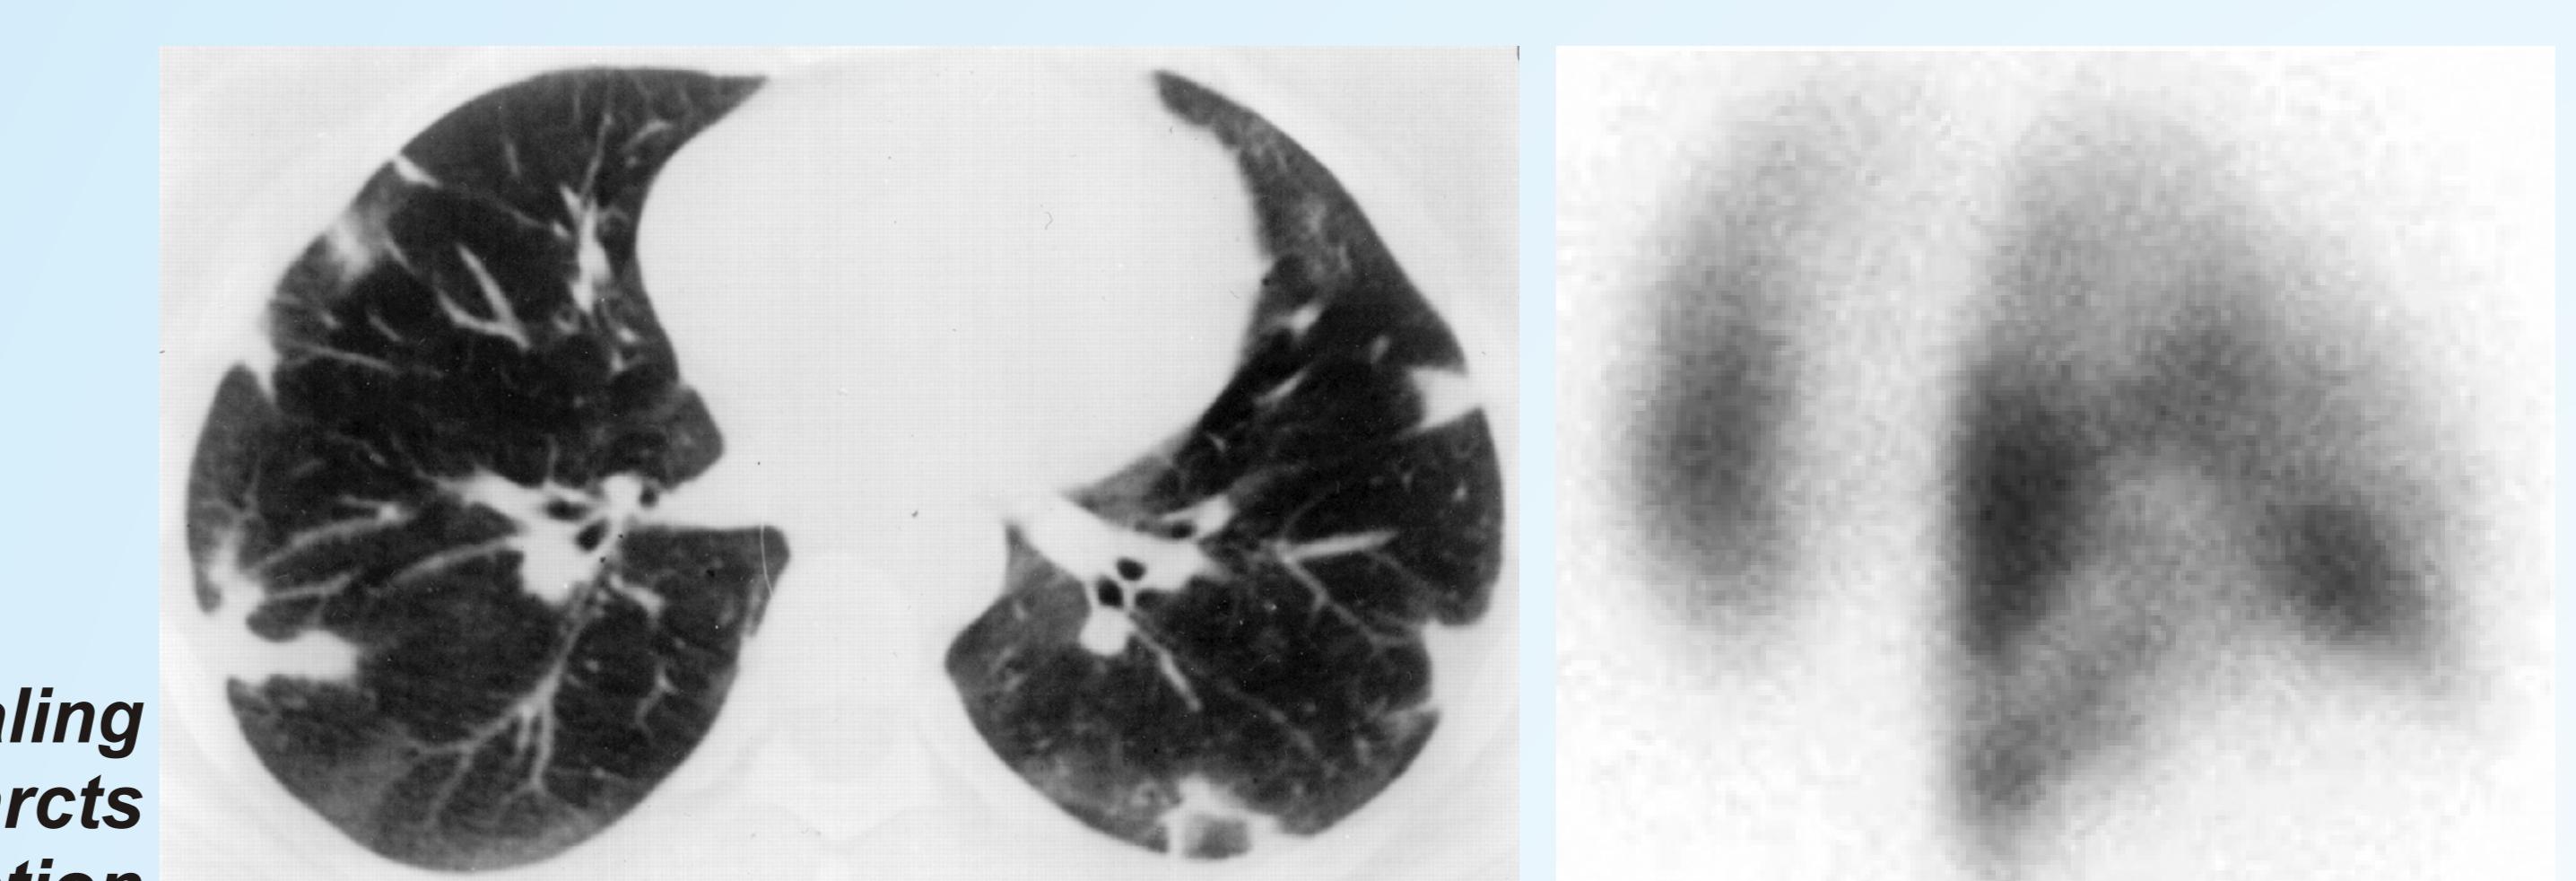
CT and scintigraphy revealing multiple pulmonary infarcts due to symptomatic embolisation
